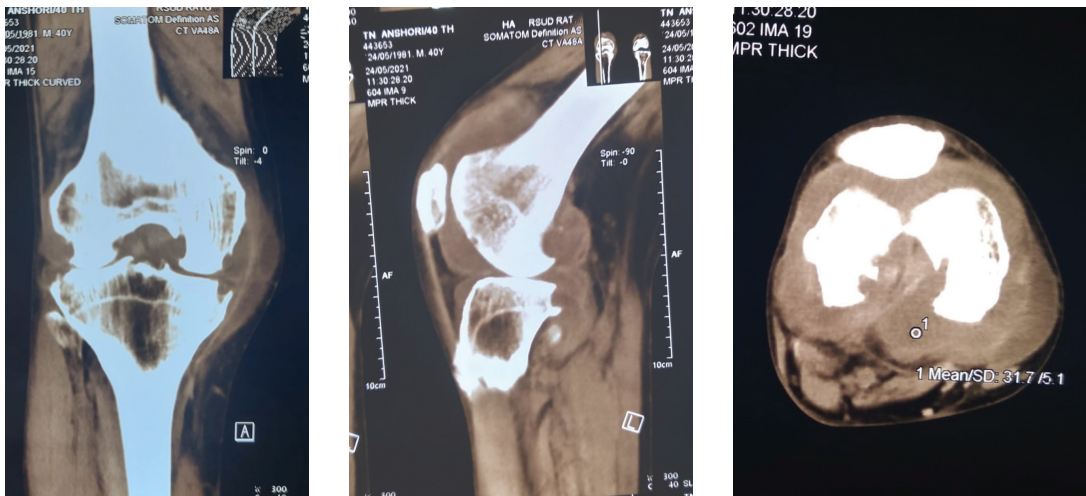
(A) Coronal slice view knee CT-scan (B) Sagittal slice view knee CT-scan (C) Axial slice view knee CT-scan
